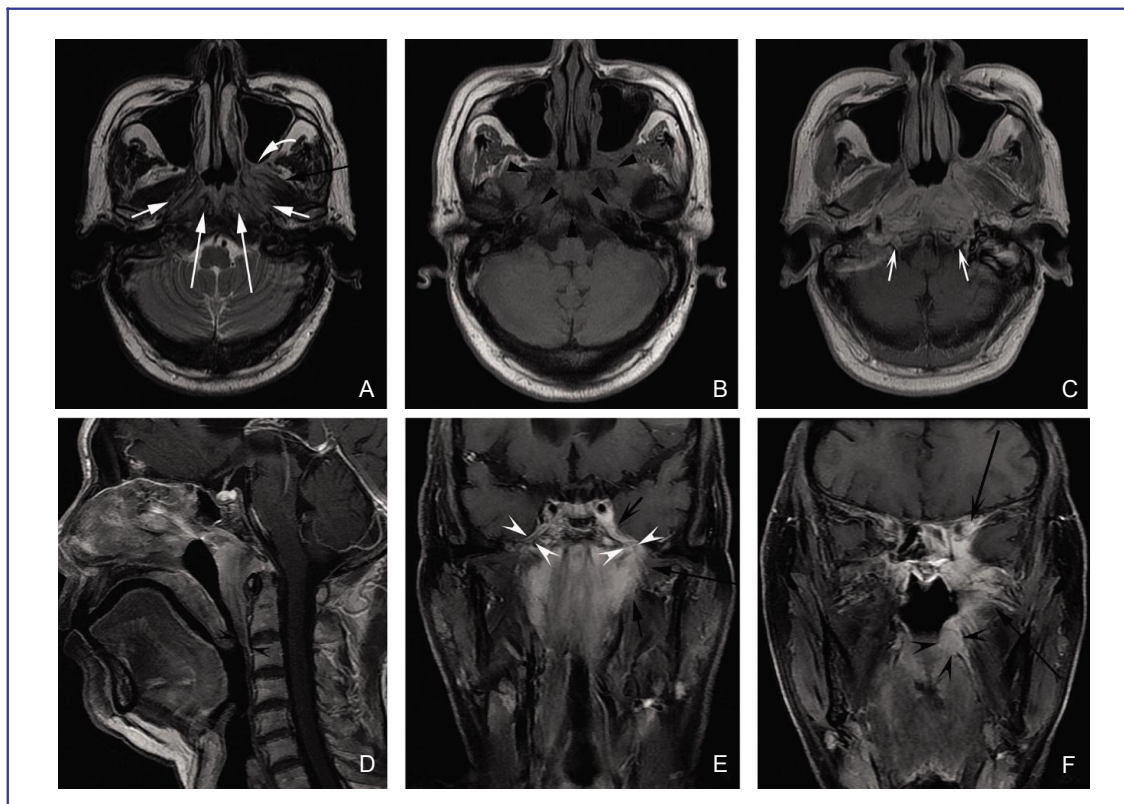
MR images of a 64-year-old man with tubular NACC. A, an axial T2W fast spin-echo image; B, an axial T1W fast spin-echo image; C, an axial contrast-enhanced T1W spin-echo image; D, a sagittal contrast-enhanced T1W spin-echo image; E, a coronal contrast-enhanced spin-echo image; F, a coronal fat-suppressed T1W image. These images show the tumor invading into bilateral parapharyngeal spaces (white arrows), bilateral retropharyngeal spaces and longus scapitis (long white arrows), left pterygopalatine fossa (curved white arrow), left medial pterygoid (black arrow), left lateral pterygoid (long black arrows), skull base bones (black arrowheads), oropharynx wall (concave black arrowheads), left cavernous sinus (concave black arrow), left orbit (long concave black arrow), bilateral mandibular nerves (concave white arrowheads), and bilateral hypoglossal canals (concave white arrows).
